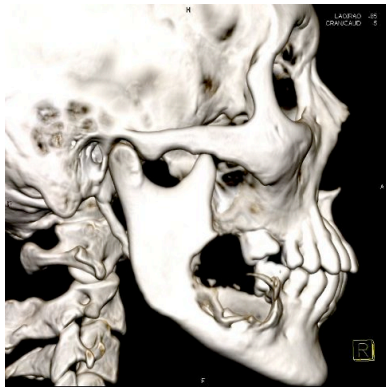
Mandible 3D CT image before surgery
